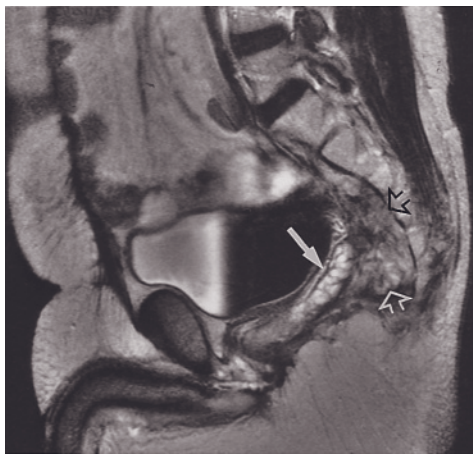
Posttreatment fibrosis. Transverse (a) and sagittal (b, c) 512-resolution T2-weighted echo-train spin-echo images demonstrate low signal intensity in the surgical bed (arrows, a–c) consistent with fibrosis. Fibrosis has a plaquelike morphology, whereas recurrence tends to be more nodular. A Foley catheter is in place (long arrow, b). SGE (d) and 4-min postgadolinium SGE (e) images in a second patient show thickening of the rectal wall (long arrows, d, e) and perirectal tissue (arrowheads, d, e). Prominent perirectal strands are also present (short arrows, d, e). Negligible enhancement is consistent with perirectal fibrosis. The perirectal halo of fibrotic tissue is a common finding after radiation therapy for rectal cancer. Sagittal (f) and transverse (g) 512-resolution T2-weighted fat-suppressed echo-train spin-echo images and interstitial-phase gadolinium-enhanced fat-suppressed SGE image (h) in a third patient demonstrate platelike tissue in the presacral space that is low in signal intensity on T2-weighted images (arrows, f, g) and does not enhance substantially after gadolinium administration (arrow, h). Normal seminal vesicles have a cluster-of-grapes appearance (large arrow, g) on T2-weighted images, which permits distinction from recurrent tumor.
